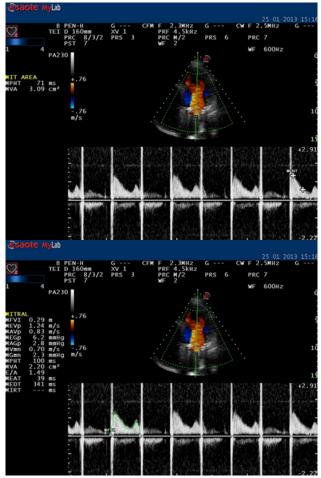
Postoperative echocardiography showed – functional and normal positioned prosthetic mitral mechanical valve SJM no. 29 (a, b)
